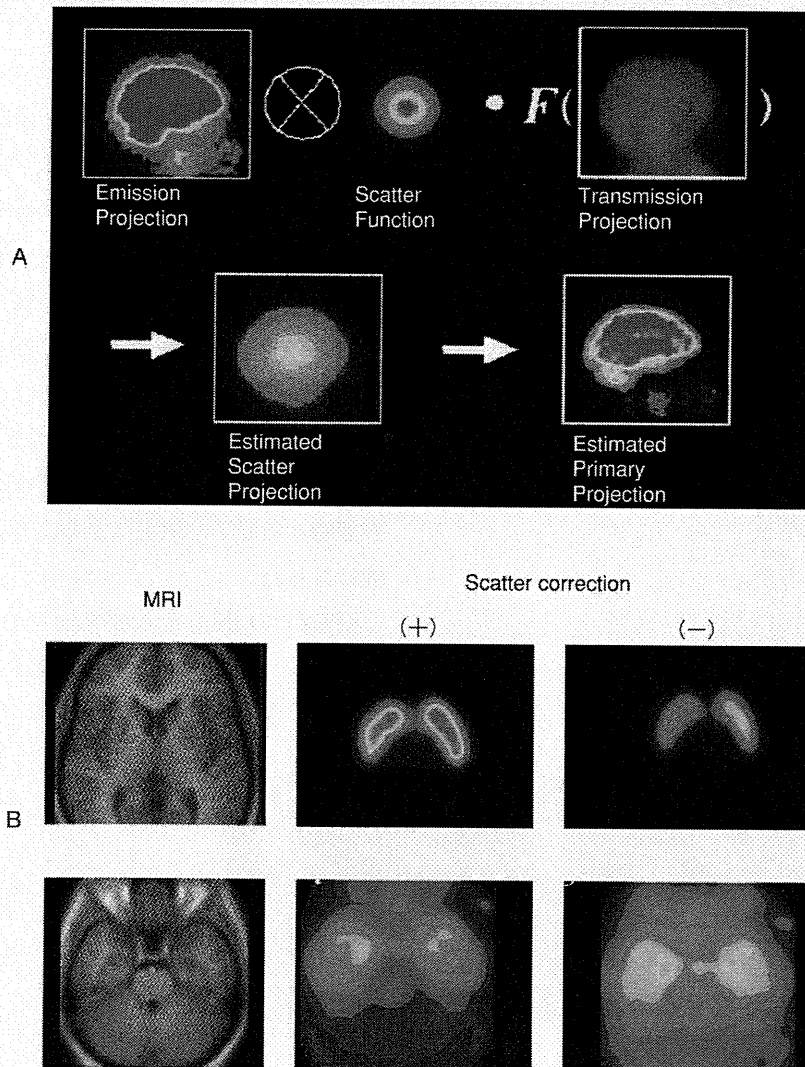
定量的 SPECT 画像再構成における散乱線補正の効果
